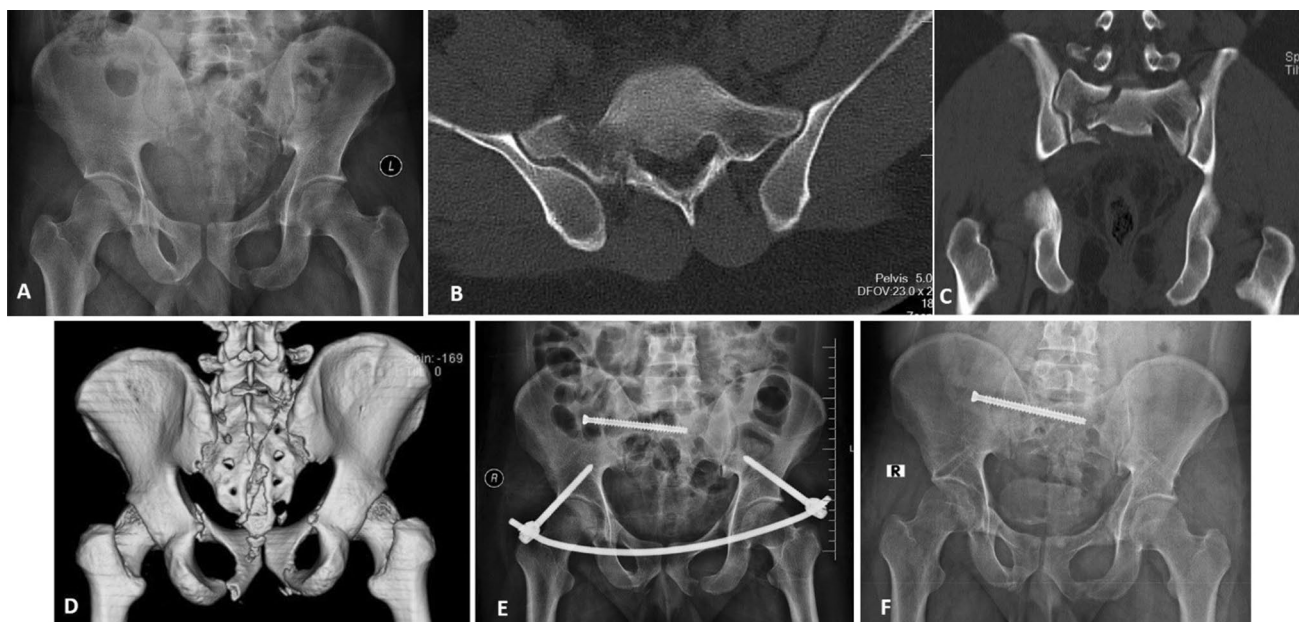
Antero-posterior radiograph (A), axial CT (B), coronal CT (C) and 3D reconstructed images (D) of Isler's type 2b fracture with fracture displacement. In the 3D image, the fracture line exits medial to the L5-S1 facet joint and associated with subluxation. The fracture
